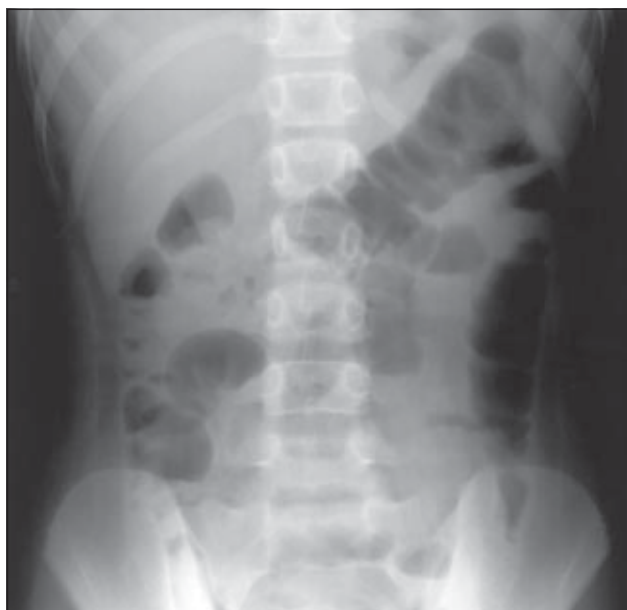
Erect abdominal radiograph showing dilated bowels with multiple air-fluid levels
